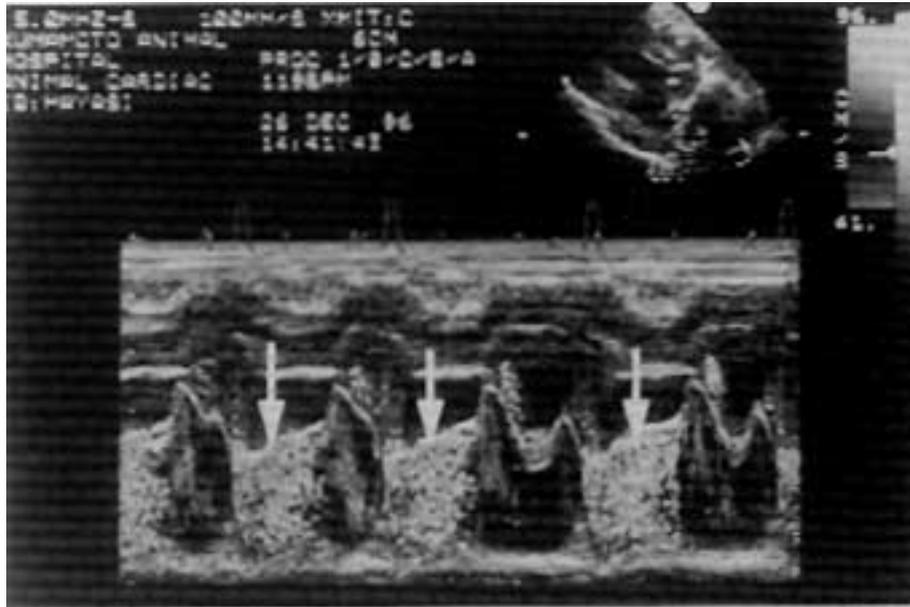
M-mode color Doppler echocardiogram in the right parasternal long-axis view; With M-mode method set at aliasing velocity of 41 cm/s, regurgitation time of one heart rate was obtained. It is indicated by arrow.
